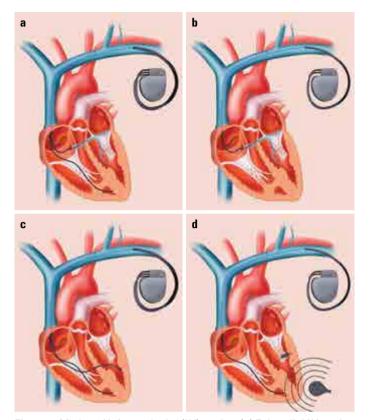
Modes of left ventricular (LV) pacing. (a) Epicardial LV pacing with an electrode (with two or four poles) lodged in the coronary sinus, one to right ventricular apex and one in the right atrium. This configuration may be used to deliver both standard BVP and pLV pacing—see text for differences. (b) Monoventricular epicardial LV pacing (mLV pacing). Note absence of RV electrode. The totality of the heart is activated with a rightward direction (not leading to QRS duration shortening). (c) Endocardial LV pacing—interventricular septum approach—an alternative approach using standard devices, allowing for more versatility in LV site selection. (d) Endocardial LV pacing—the WiSE study approach—although allowing for the greatest versatility regarding site, it does not use CRT devices, rather a dual-chamber pacemaker communicates with an ultrasound generator that in turn activates the electrode in the left ventricle
